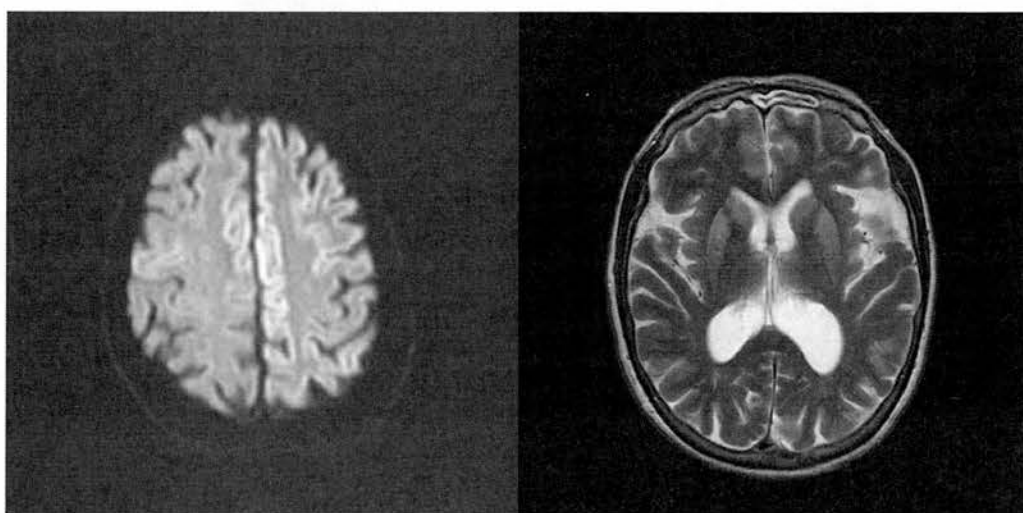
MRI showing cortical (left) and basal ganglia (right) high signal on DWI sequences in sCJD (14)
